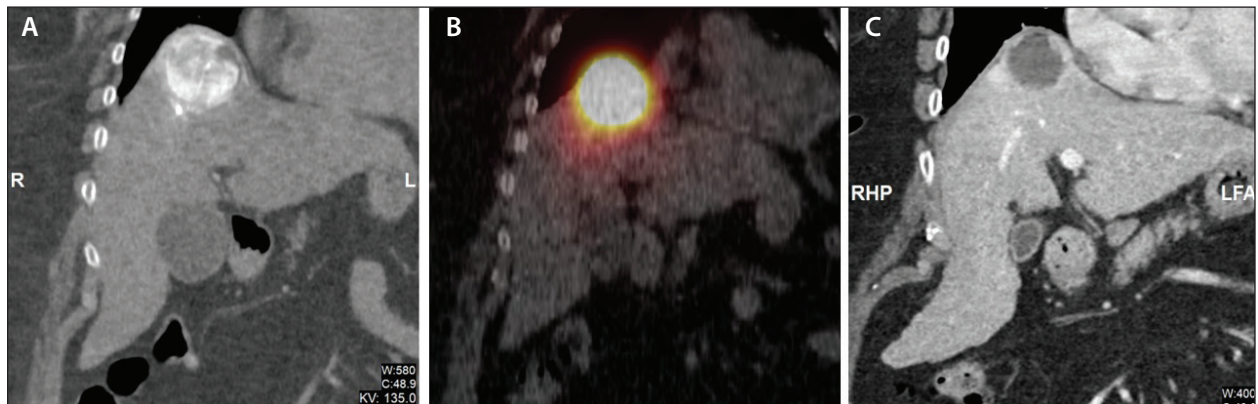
A woman in her mid 60s with a solitary HCC treated with radiation segmentectomy using resin yttrium-90 microspheres. Intraprocedural CT images with selective contrast injection into a segment 8 branch of the right hepatic artery showed a hyperenhancing tumor in segment 8 (A). Postradioembolization bremsstrahlung single-photon emission CT/CT images demonstrated distribution of radiomicrospheres in the target tumor (B). Follow-up contrast-enhanced CT 6.5 months after radioembolization demonstrated complete response with lack of enhancement in the treated tumor (C).
